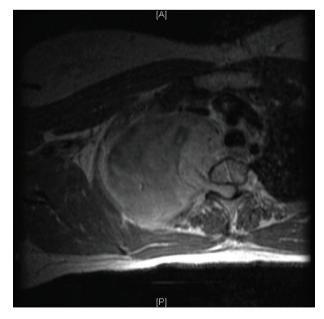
MRI T1 transverse view of the thoracic cage.
